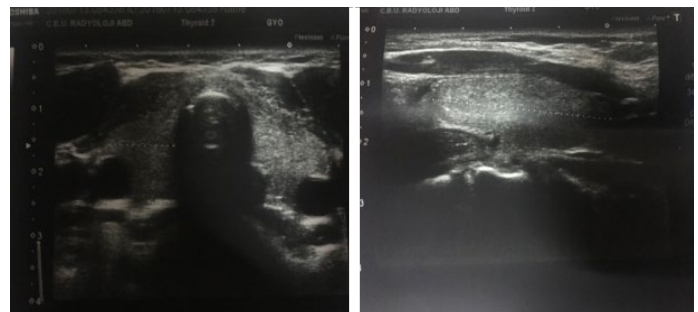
Ultrasonography of the neck and the grafted left front arm.
